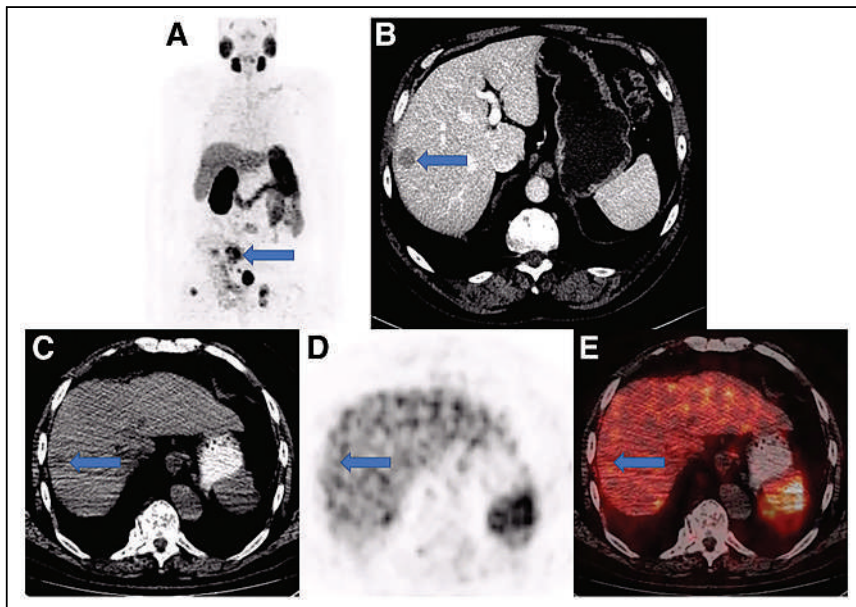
Example of patient who would have been excluded by imaging selection criteria used in VISION trial. (A) Anterior maximum-intensity projection from ^{68}Ga -PSMA-11 PET/CT has readily evident PSMA-positive disease, such as in sacrum (arrow); thus, next step is to evaluate diagnostic CT for lesions that fulfill size criteria for possible exclusion. (B) On contrast-enhanced diagnostic CT, 1.8-cm metastasis is identified in right hepatic lobe (arrow). Transaxial low-dose CT (C), PET (D), and PET/CT (E) images show that metastasis (arrows) has activity similar to normal liver, is therefore PSMA-negative, and would result in exclusion. Level of uptake in hepatic metastasis was importantly confirmed in sagittal and coronal planes (not shown) in case of misregistration.
